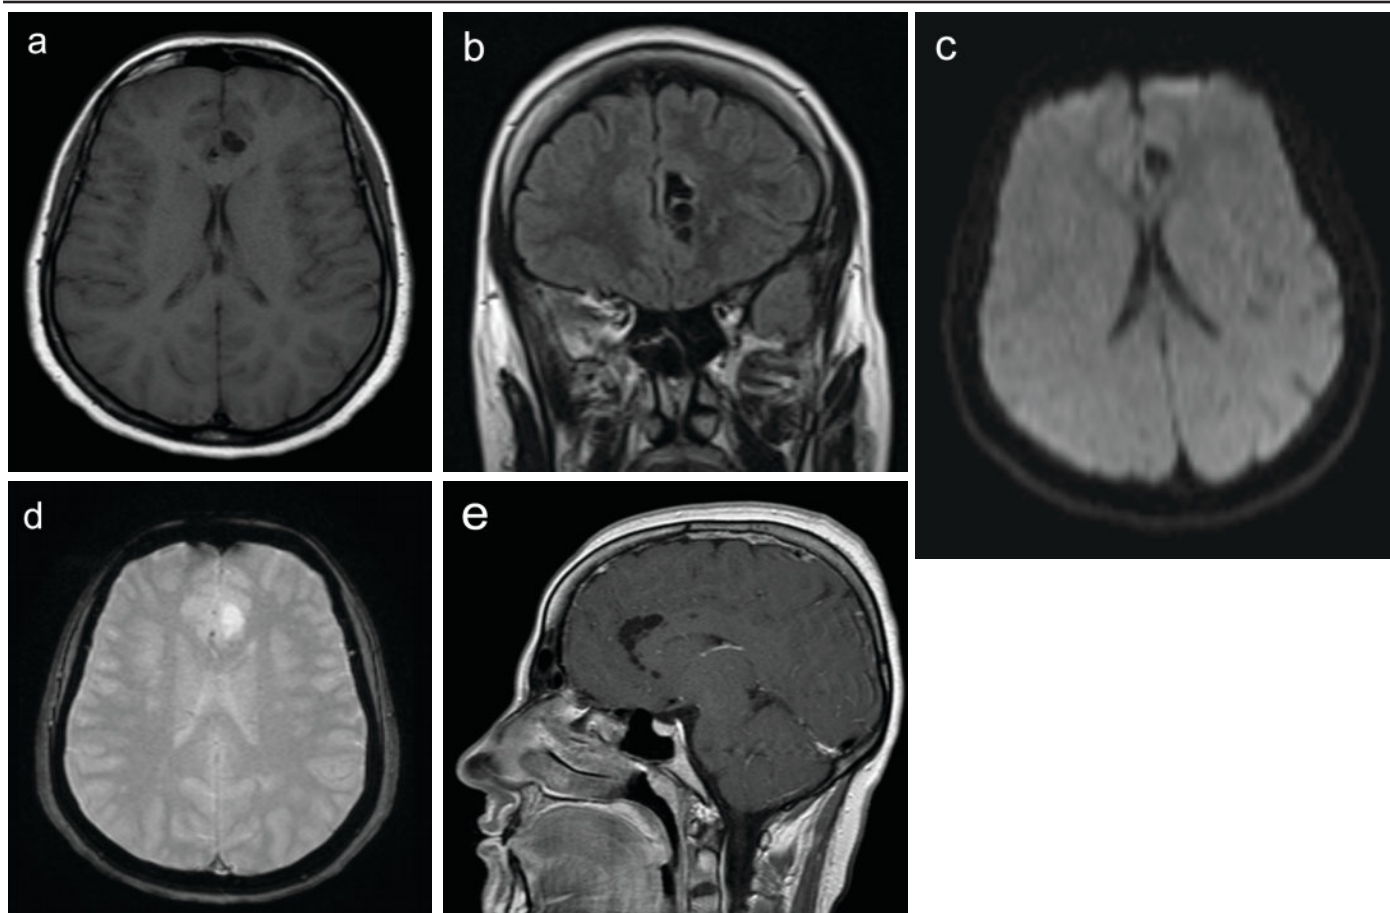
Axial T1-weighted (repetition time - TR:550ms, echo time - TE:10ms, averages:4, flip angle:90°) images (a) shows parasagittal hypointense multicystic lesions in cingulate gyrus that completely suppressed in FLAIR (TR:8000ms, TE:118ms, averages:1, flip angle:150°) images (b). There is no restriction diffusion-weighted (b-value:1000) images (c) and no calcification or haemorrhage in T2W-Fast Field Echo (TR:757ms, TE:23ms, averages:2, flip angle:18°) sequence (d). No contrast enhancement in T1-sequence was detected (e).
